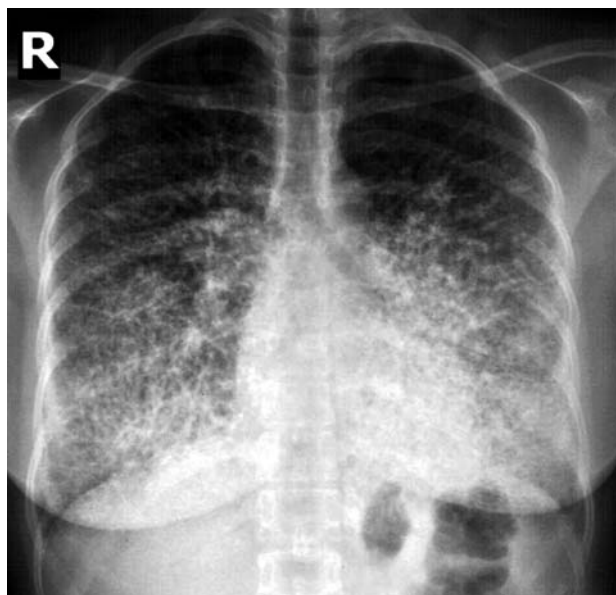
Chest radiograph (postero-anterior view) showing bilateral dense reticulonodular opacities.
